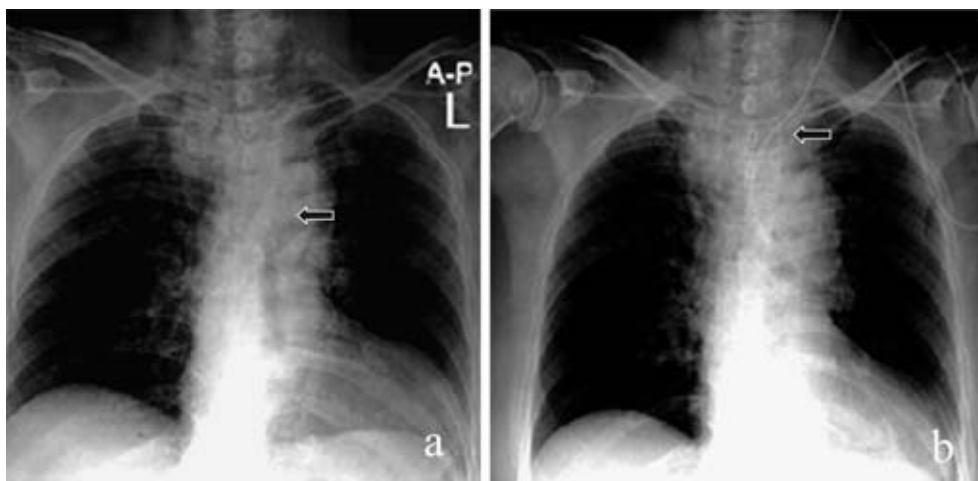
a: A plain chest X-ray film immediately after perforation showed a translucent area along the esophagus indicating air accumulation (arrow), b: Mediastinal drainage tube along the trachea is shown (arrow).
